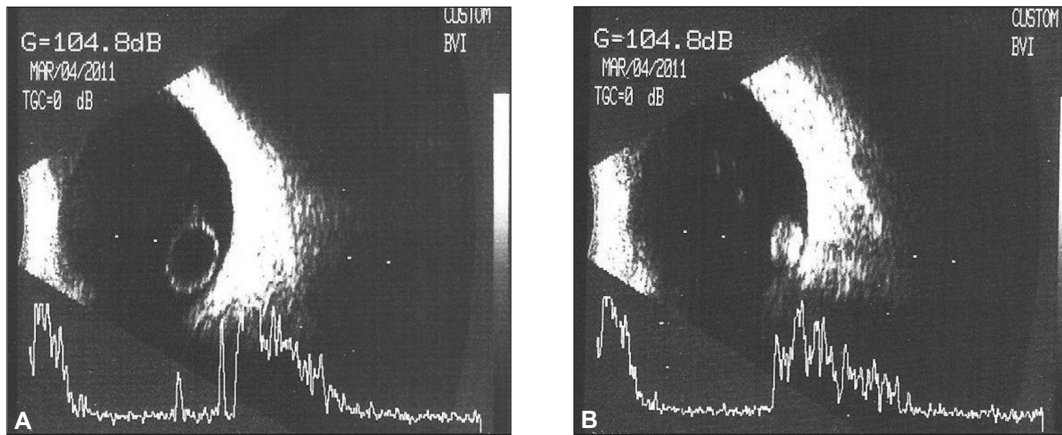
b-mode ultrasonography revealed bilateral posteriorly dislocated lenses into the vitreous body in both eyes.
